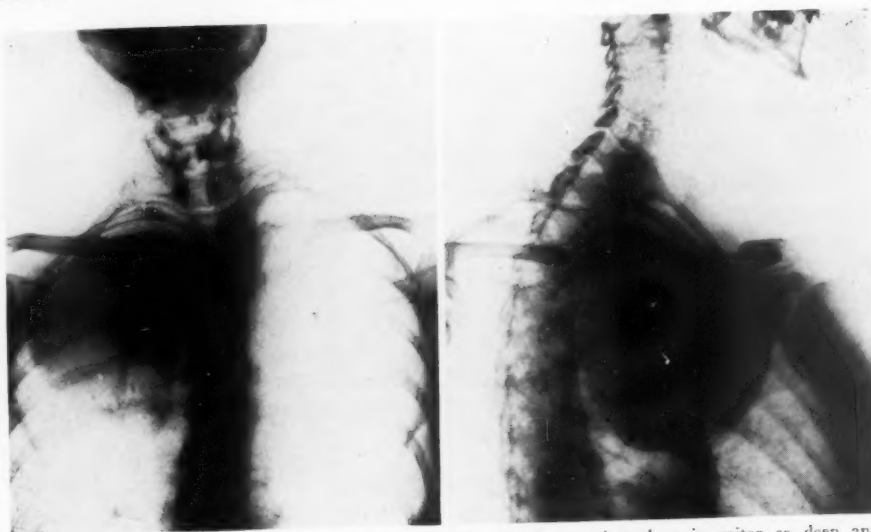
Anteroposterior and lateral roentgenogram showing an intrathoracic goiter so deep and so large that its removal could be successfully accomplished only after removal of the inner half of the clavicle and the manubrial portion of the sternum. Dissection of the recurrent laryngeal nerve in this case, as in many other cases of intrathoracic goiter, shows the only distortion of the course of the nerve to be in an inward direction against the trachea (Fig. 6), where it is less likely to be injured by the removal of the intrathoracic extension than when in its normal position.
